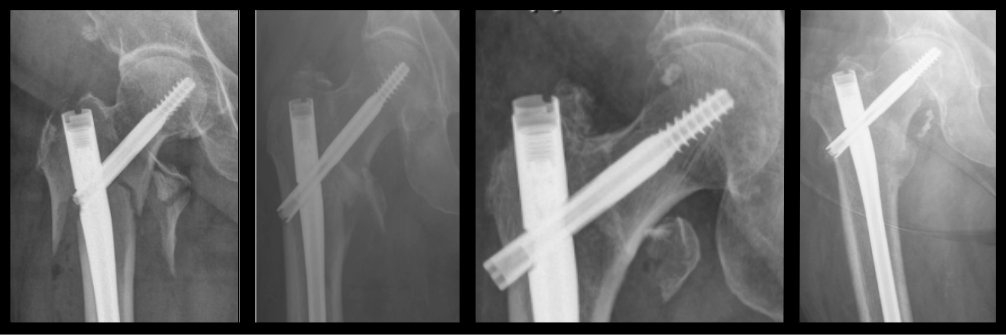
Radiographs of inadequate proximal femoral fixation points with (A) lag screw short of the lateral cortex (B) end cap of nail distal to greater trochanter (C) TAD > 25 mm, and (D) poor nail fit
